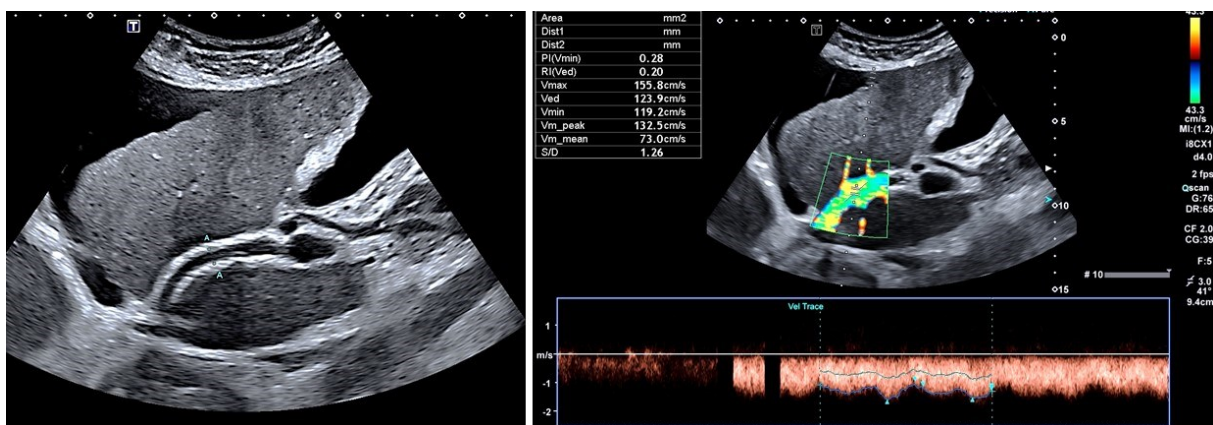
a.7. Ultrasound imaging of the transjugular intrahepatic porto-systemic stent shunt (TIPS). On B-mode imaging TIPS looks as the curvilinear tubular structure with echogenic walls, and patent lumen, inserted between the right hepatic vein and portal vein (left panel). On Doppler studies there is flow through the TIPS directed towards the right hepatic vein, with mean peak velocity of 132 cm/s, which is considered normal (right panel).
